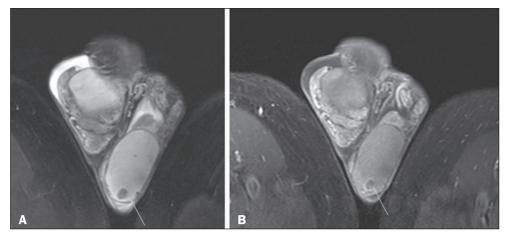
Leydig cell tumor. Coronal fatsaturated T2-weighted image (A) and dynamic contrast-enhanced sequence (B, delayed phase), showing a solid nodule in the lower pole of the left testis, with low signal intensity on the T2-weighted image (A), early enhancement on a dynamic contrast-enhanced sequence (image not available), and washout in the delayed phase (B).
